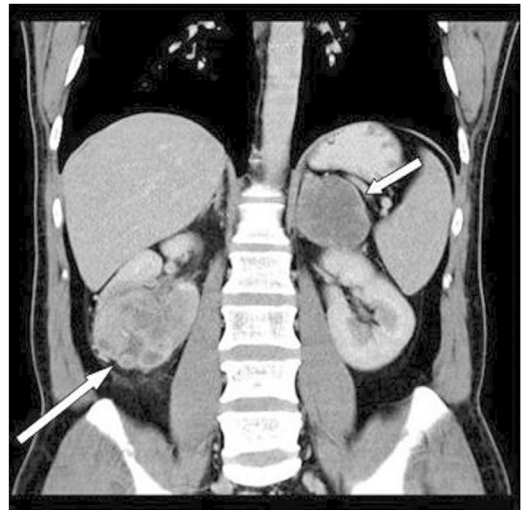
Coronal CT slice demonstrating a left-sided adrenal metastasis (short arrow) from a right-sided renal cell carcinoma (long arrow). (Image obtained from Öztürk H. Bilateral synchronous adrenal metastases of renal cell carcinoma: a case report and review of the literature. *Oncol Lett* 2015;9(4):1897–901. <https://doi.org/10.3892/ol.2015.2915> under Creative Commons Attribution License.⁵⁴)
